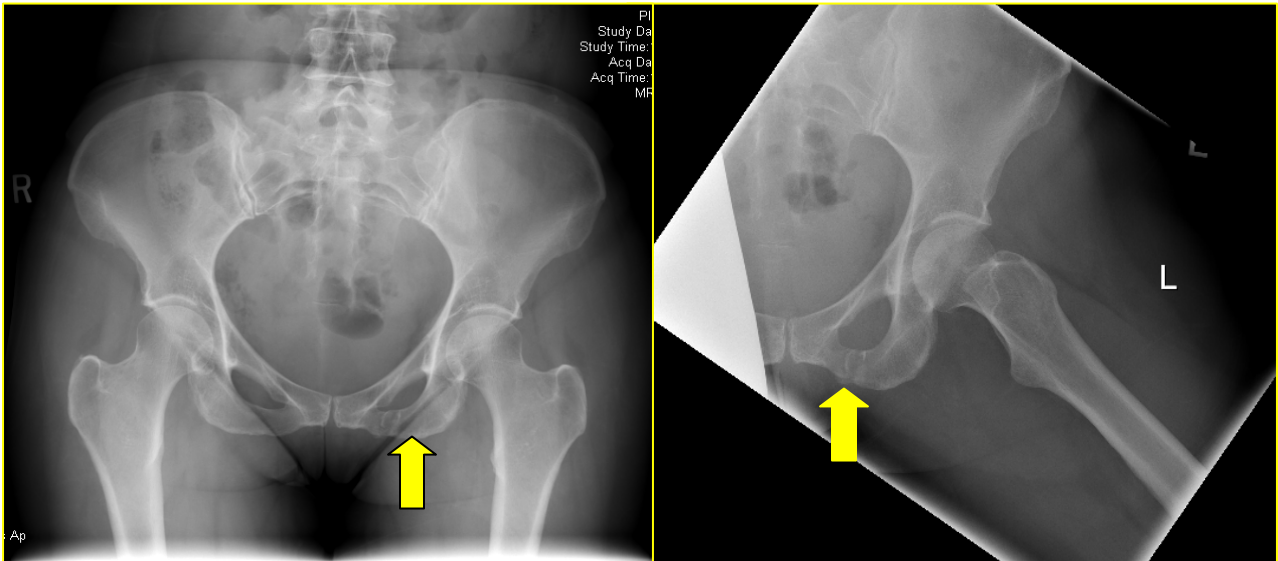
Pelvis and Hip x-rays demonstrate inferior pubic ramus fracture
